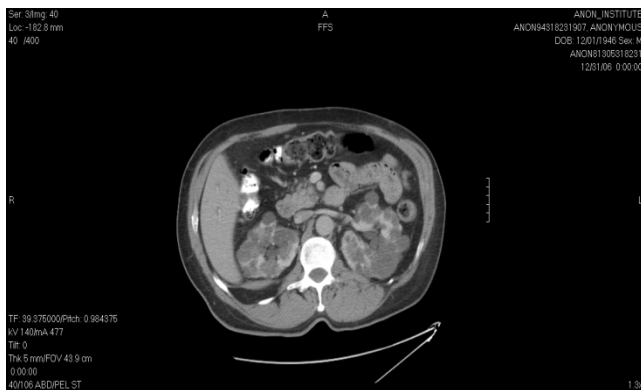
CT Abdomen in our patient showing PCKD.
